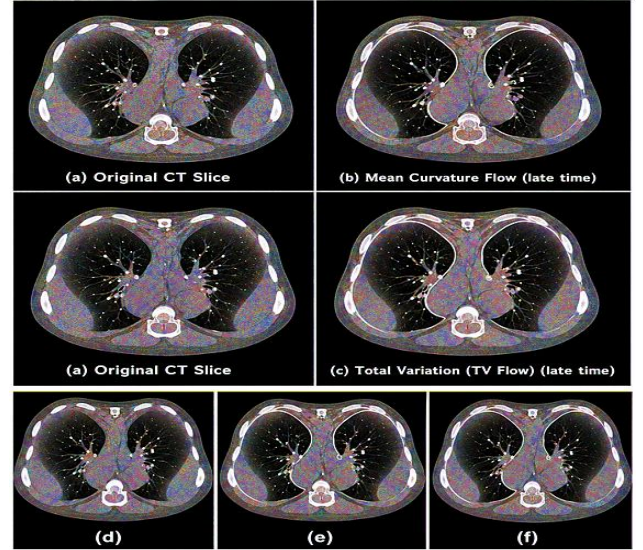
Edges are preserved well in the TV flow compared to the mean curvature flow. (a) Original CT slice, (b) TV flow, and (c) Mean curvature flow.
